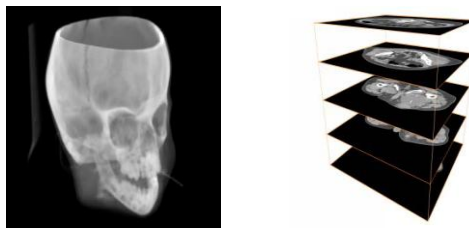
3D CT Dataset of a Human Head and 2D CT Slices.
